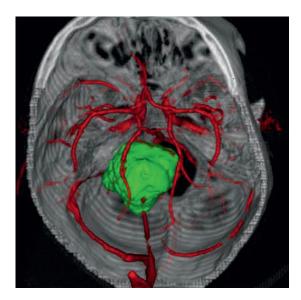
A 3D visualization of an acoustic neuromas patient. The image demonstrates the relationship between the skull (identified on CT), an acoustic neuroma (identified on contrast enhanced MRI) and the adjacent blood vessels (identified on time of flight angiography)
